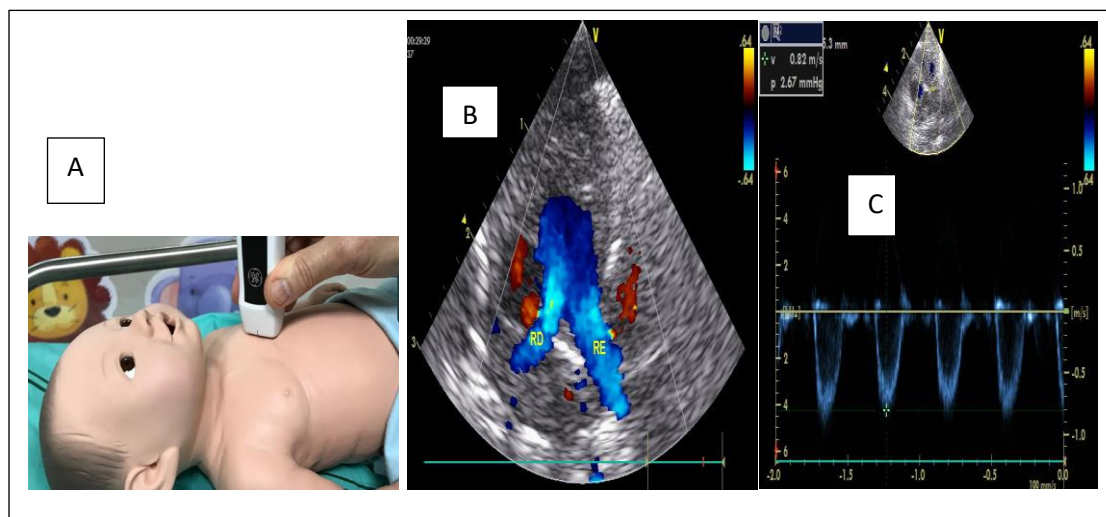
Short axis parasternal window. A) Positioning of the transducer with the marker directed to the left and placing the transducer anteriorly. B) Image of the trunk and branches of the pulmonary artery. C) Analysis of pulmonary artery flow velocity.
